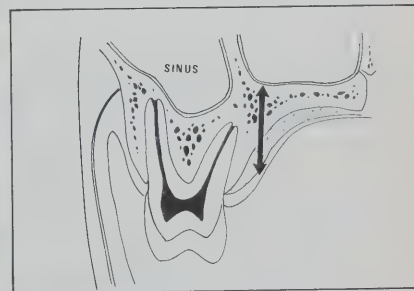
The relationship between the teeth and the antrum and inner nose. Note the thinness of the bone over the periapical areas and the buccal roots. Sometimes the apices may be directly in the antrum, covered only by a thin mucous membrane.
